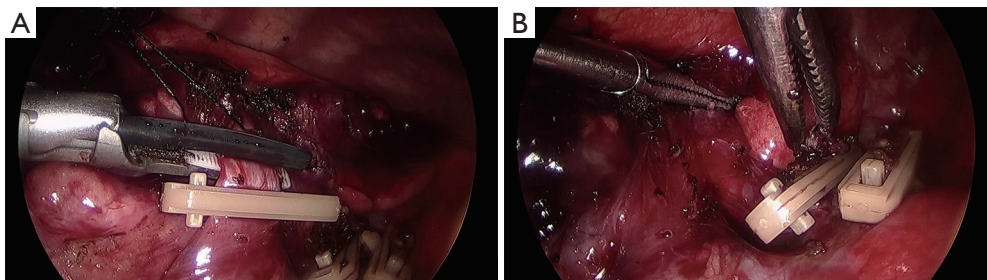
A 21-day-old boy with congenital pulmonary airway malformation in the lower lobe of the right lung. Images taken during thoracoscopic surgery showed that: (A) Ligating the vein returning to the lower lobe of the right lung with an absorbable clip; (B) disconnecting the vein with ultrasonic scalpel.
